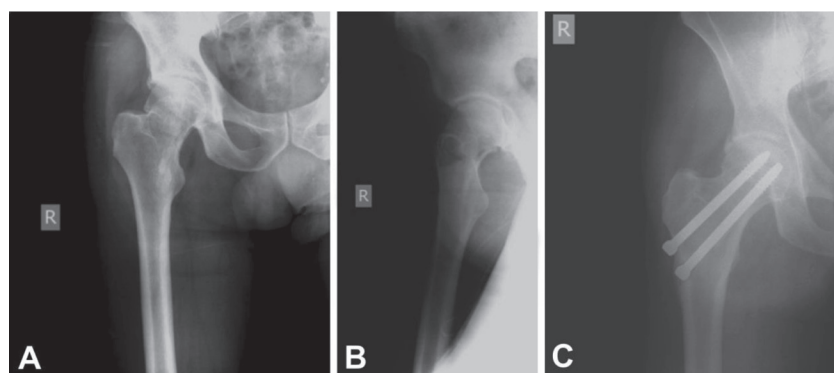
A – effect of "biological plate": anteroposterior view of femoral neck fractures with posterior wall comminution in a 63-year-old male patient; B – profile view indicated disrupted posterior wall of femoral neck fractures; C – six months postoperative X-ray show significant thickening of the lateral cortex around the distal screw with fracture healing
